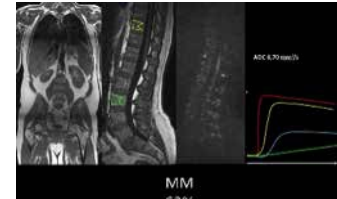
WB-MRI, DCE-MRI (+TIC) and DWI in multiple myeloma with 62% plasma cells
